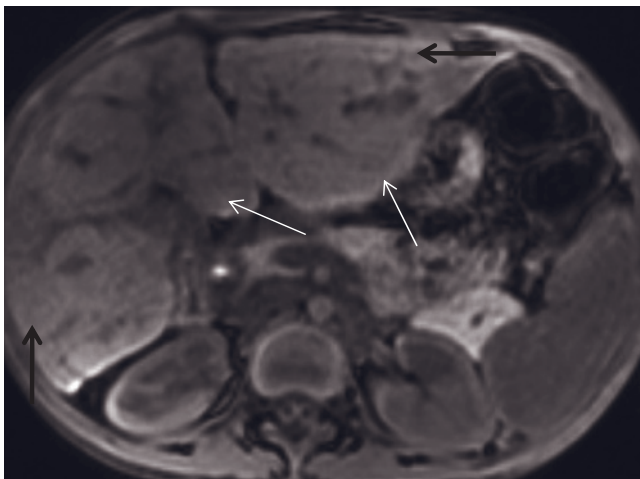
Primary sclerosing cholangitis (PSC) with cirrhosis. T2-weighted fat-suppressed single-shot echo-train spin-echo (a), T1-weighted SGE (b), and 2-min postgadolinium fat-suppressed SGE (c) images. The intrahepatic bile ducts are dilated and demonstrate beading. The liver is nodular and cirrhotic in this patient with late-stage PSC. Three large macroregenerative nodules (long arrows, a, b) located in the central portion of the liver appear to obstruct the bile ducts centrally. The nodules are slightly hypoenhancing on the 2-min postgadolinium image (c). A subsegmental distal area of atrophic liver parenchyma (short arrows, a, b) appears slightly hyperintense on the T2-weighted image (a) and hypointense on the T1-weighted image (b). T2-weighted fat-suppressed single-shot echo-train spin-echo (d), T1-weighted SGE (e), and 2-min postgadolinium fat-suppressed SGE (f) images in a second patient. The liver shows multiple large macroregenerative nodules. The bile ducts in the right lobe of the liver are severely dilated and contain several calculi (arrows, d-f) that are high signal on the T1-weighted image (e). A wedge-shaped peripheral area of liver parenchyma (short arrows, d-f) is atrophic, showing high signal on the T2-weighted image (d) and low signal on the T1-weighted image (e) with late enhancement on the 2-min postgadolinium image (f). T1-weighted 2-min postgadolinium
